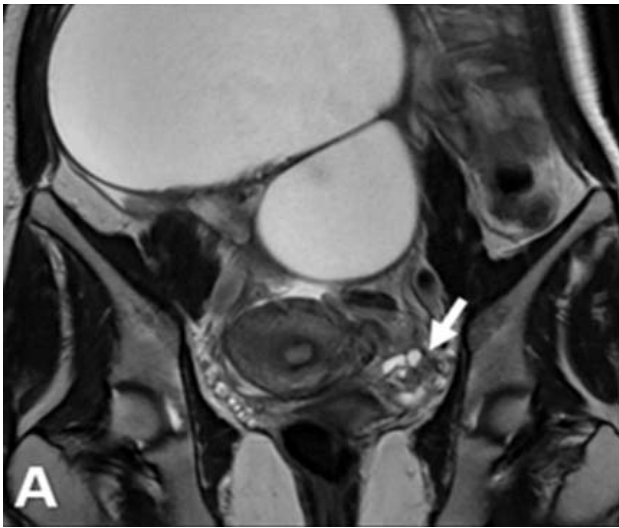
Coronal T2, T1, and T1 fat-suppressed MRI images showing a small left ovarian lesion with hyperintense foci on T1 and T2 and signal drop-out on fat-suppressed sequence (arrow), consistent with a dermoid cyst.
